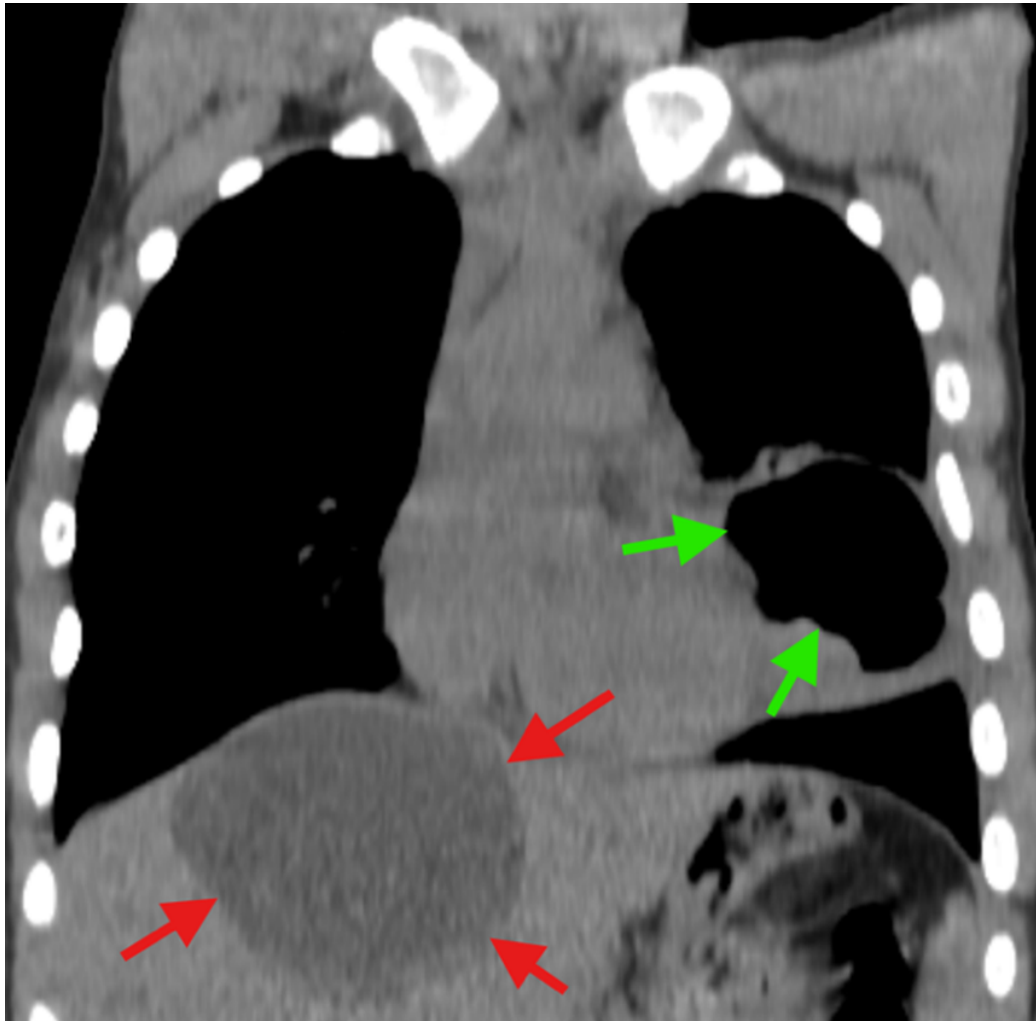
Coronal thoracic computed tomography (CT) image of hydatid cysts in lung and liver. In the coronal section of the thoracic CT, a hydatid cyst opening into the bronchus and containing air in the lingular segment is shown with green arrows, while a fluid-filled hydatid cyst extending from segment 8 to segment 7 of the liver is indicated by red arrows.
